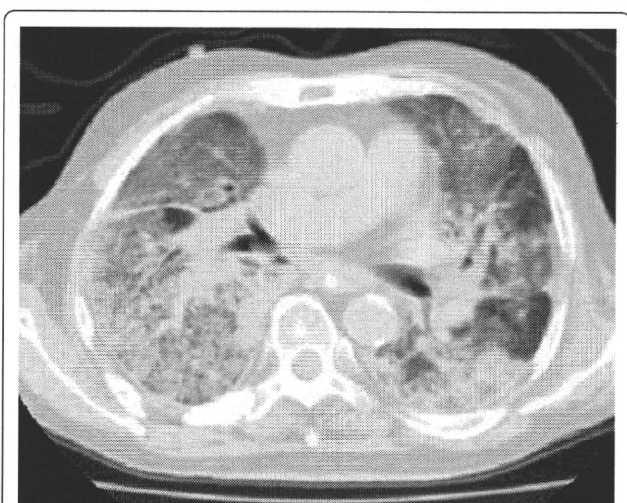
CT images of radiation pneumonitis (acute exacerbation of IP) after SBRT (Pt. No. 7).
